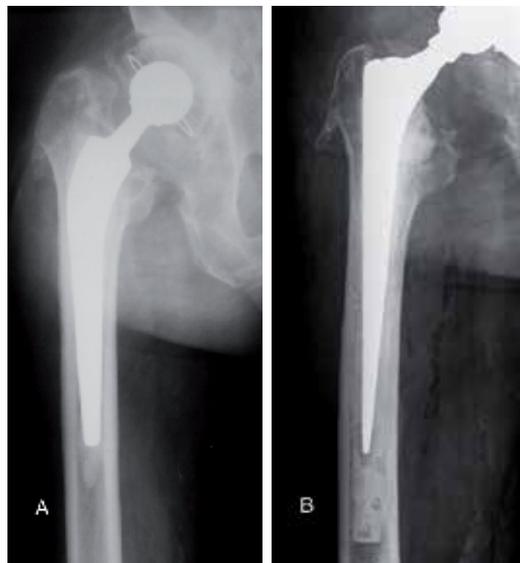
(A) Preoperative radiograph of a failed cemented prosthesis. (B) Grade A cemented fixation achieved with modern cementing technique.
